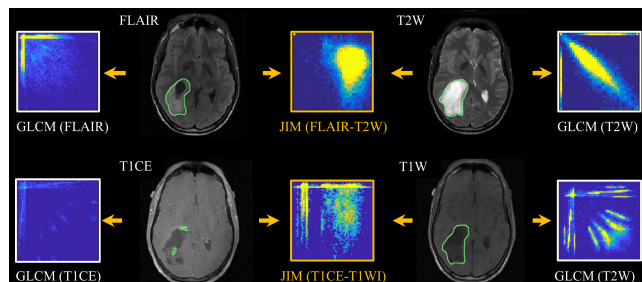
Example of GLCM and JIM co-occurrence matrices computed from segmented ROIs in FLAIR, T2W, T1CE and T1W images. GLCM features are based on a single MRI sequence (FLAIR, T2W, T1CE and T1W) while JIM is obtained from multi-parametric MRI data consisting of FLAIR-T2W and T1CE-T1W modalities.
